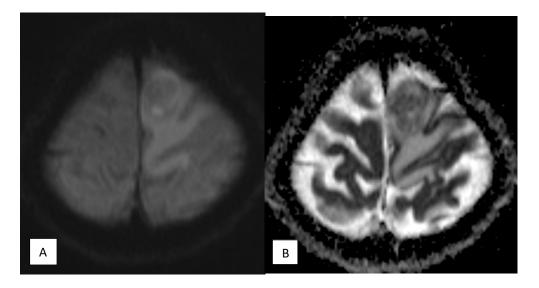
Diffusion weighted imaging features in a case of Tuberculoma MRI Brain Axial sections A) Axial DWI (B) Axial ADC map – Patchy areas of restriction of diffusion. ADC value obtained was 0.73 x 10⁻³ mm²/s
